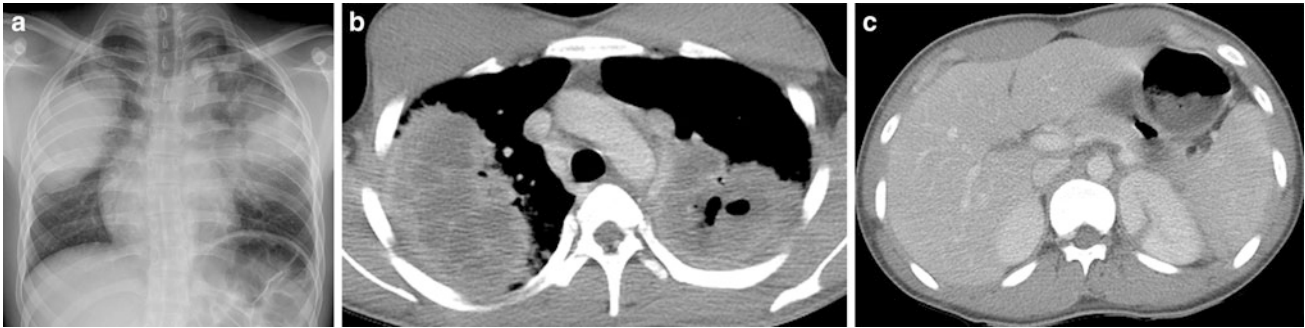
Granulomatosis with polyangiitis (GPA). A frontal CXR (a) of a 17-year-old male with hemoptysis, hematuria and elevated anti-PR3 antibodies depicts large mass-like opacities of the mid to upper lungs bilaterally. An axial contrast-enhanced chest CT image
